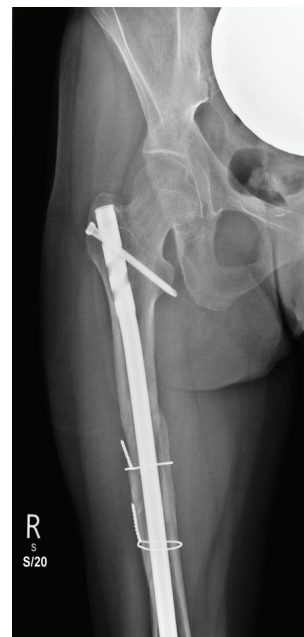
Anteroposterior (AP) and lateral radiograph post-revision fixation demonstrating the intramedullary nail revision with open reduction and cerclage wiring.
